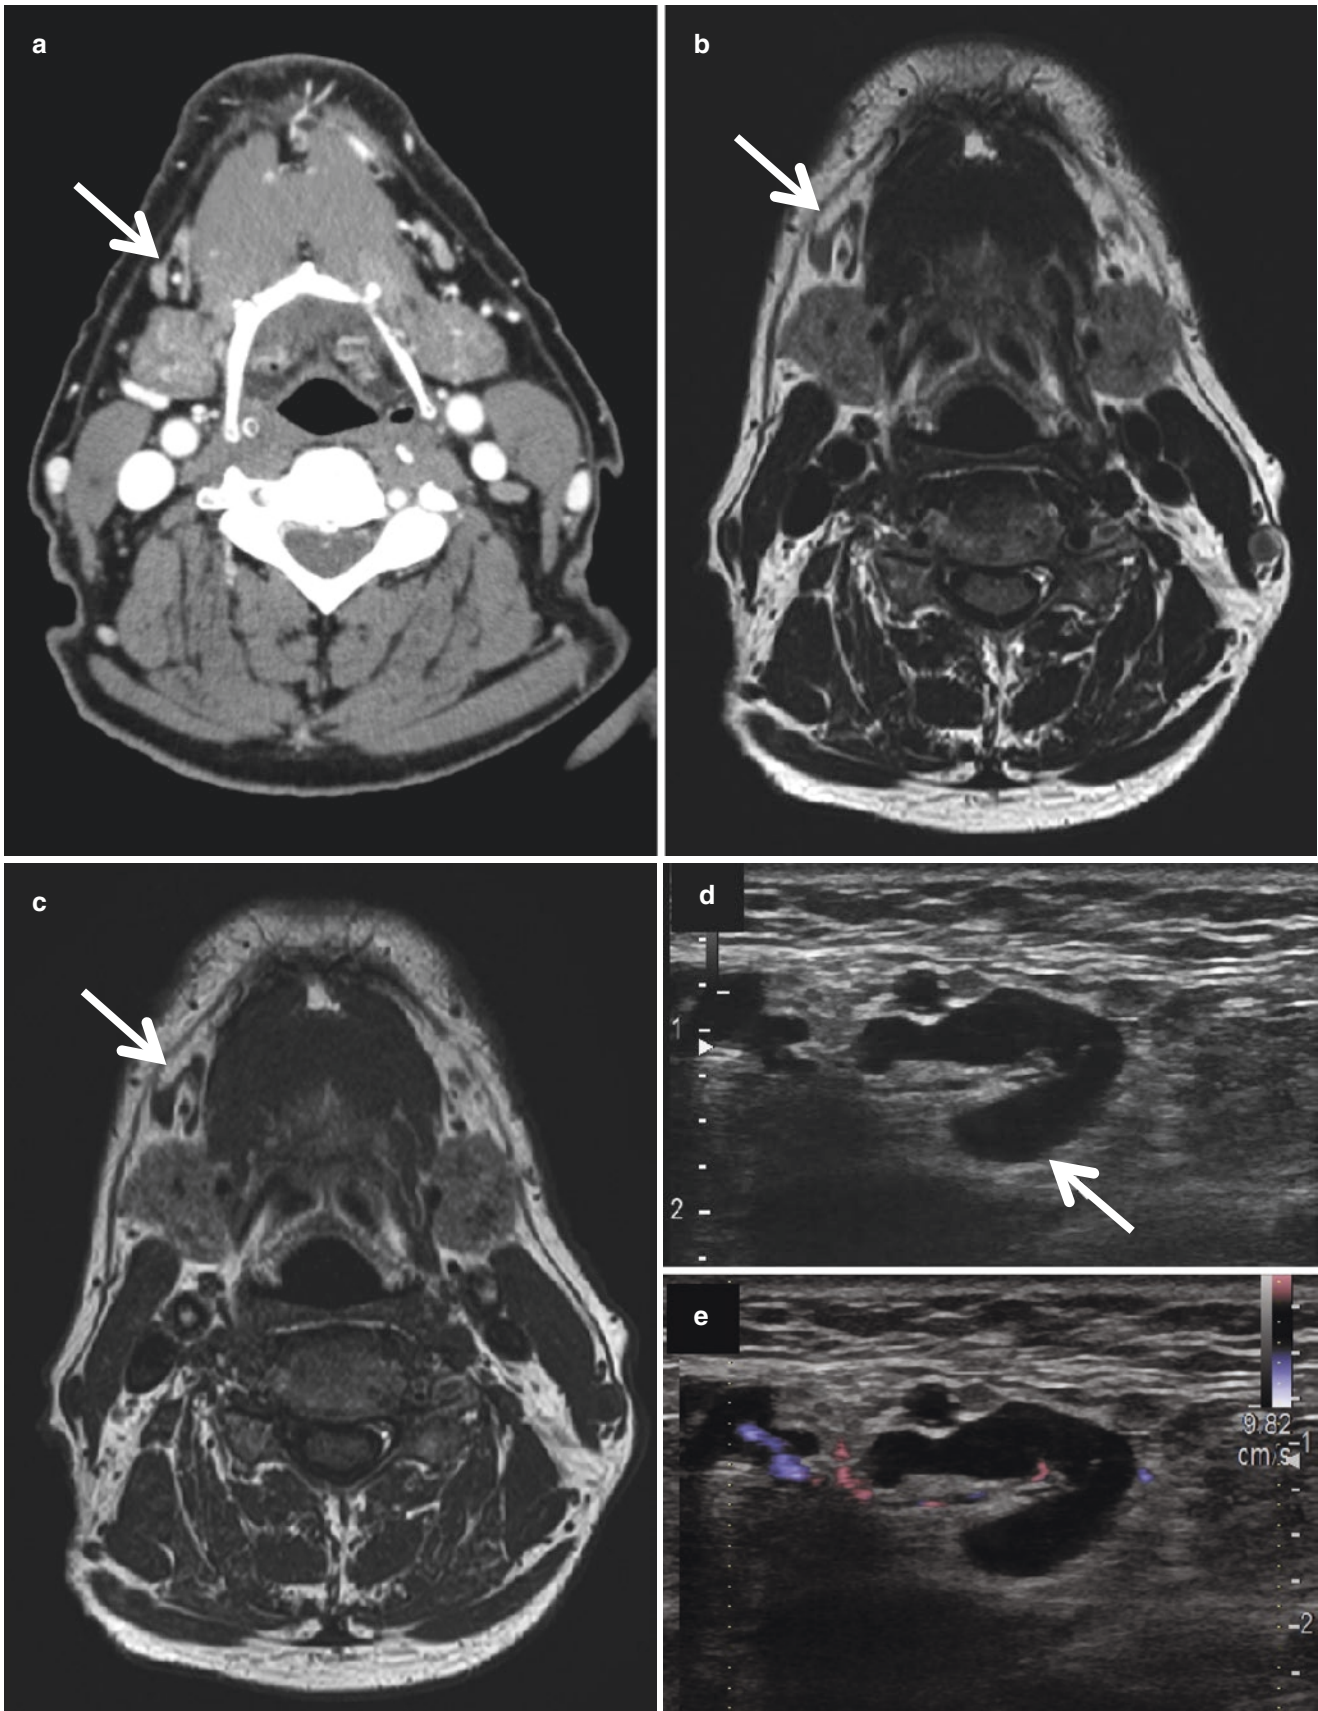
A right level IB lymph node (*arrow*) shows normal size and shape with fatty hilum on axial CECT (a), T2WI (b), and T1WI (c). US shows homogeneous parenchyma (d, *arrow*) and echogenic hilum with a hilar vascular pattern on color Doppler (e)
